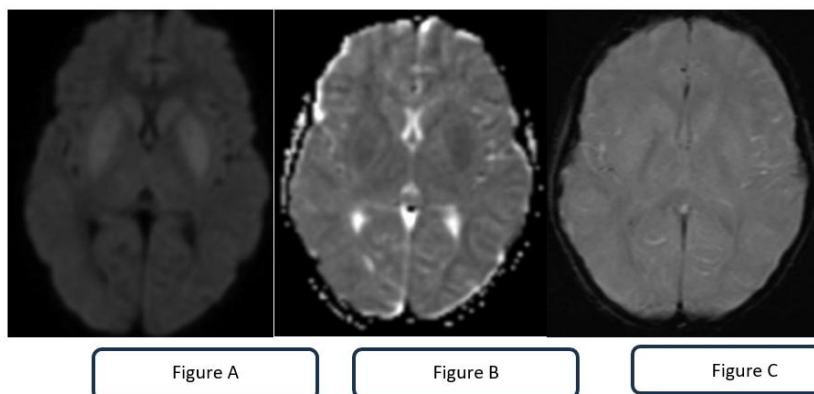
Figure A & B : Axial DWI and corresponding ADC map showing diffusion restriction.
